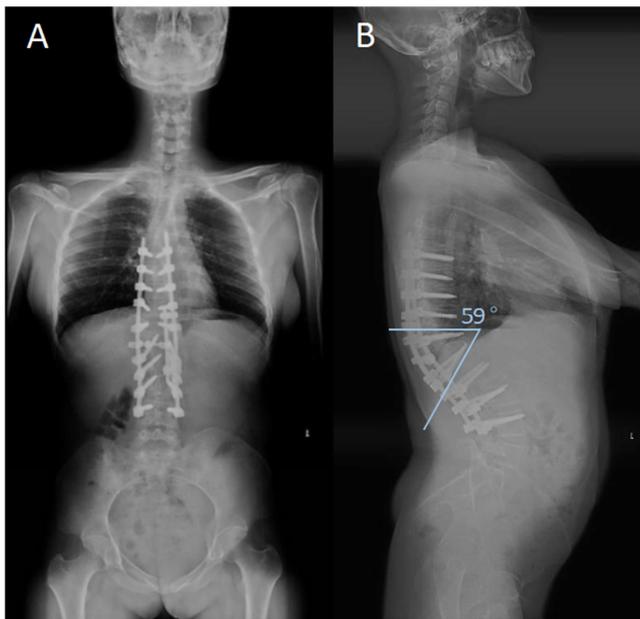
Postoperative X-ray A: Postoperative full-length X-ray coronal plane of the spine; B: Postoperative full-length X-ray sagittal plane of the spine. The local kyphosis angle is 59° , which is 78° better than that before operation.
